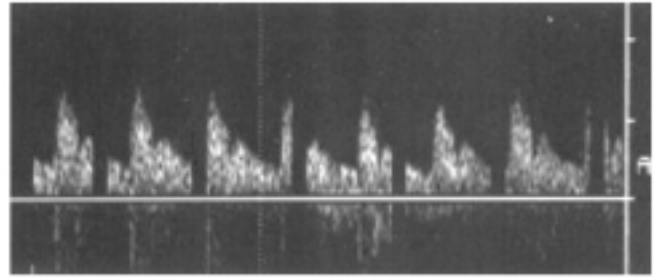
Postoperative Doppler waveform tracing for patient with GEA graft without complications at one year
